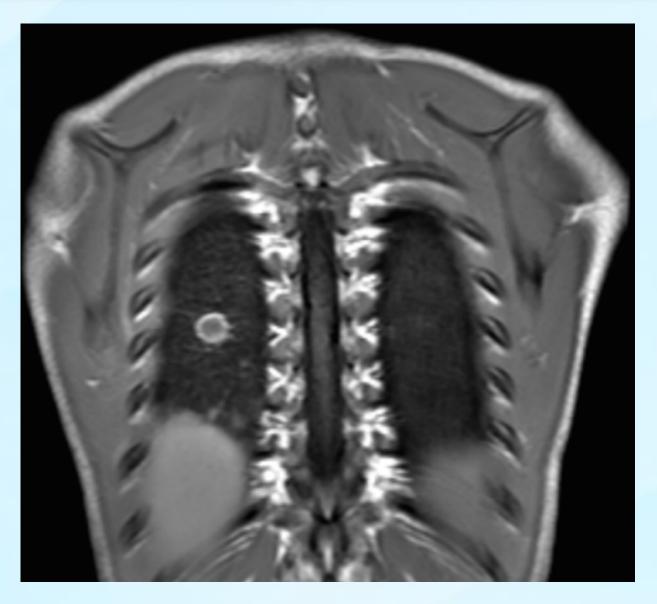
MRI Chest: Cystic lesion in R lung adjacent to pleura.
